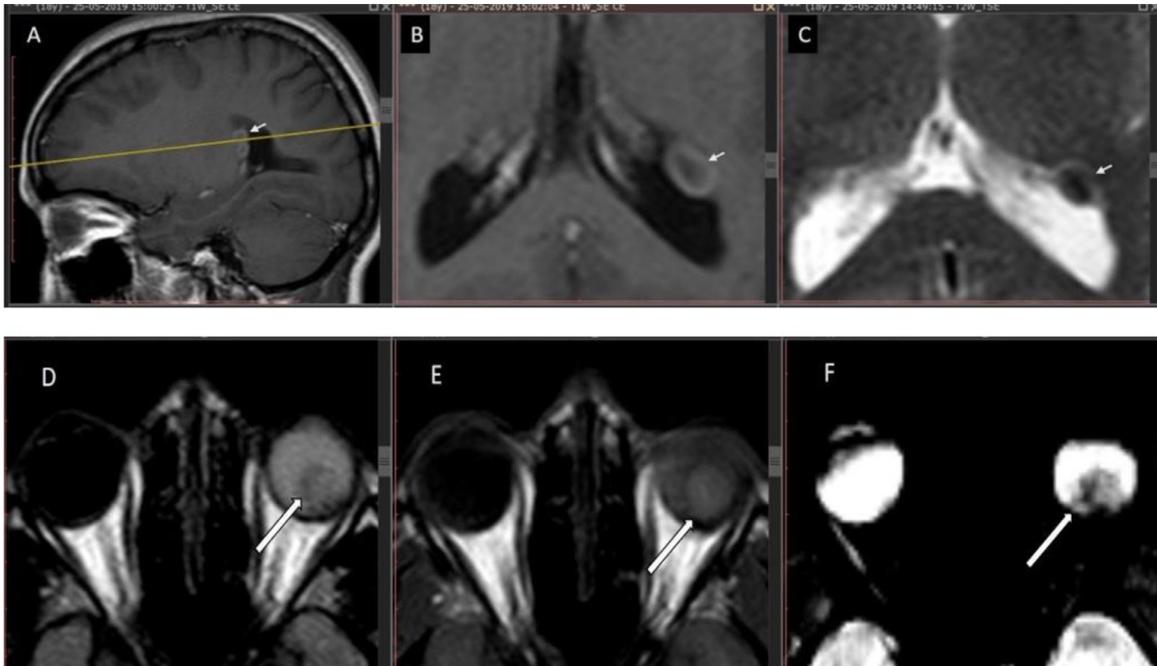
Contrast-enhanced MRI Brain shows round to oval enhancing mass lesion (white arrows) arising from the antrum of the left lateral ventricle (A and B), in close proximity to the foramen of Monroe appearing peripherally hyperintense with central hypointensity on T2W image (C) and shows round to oval enhancing mass lesion (white arrows) arising from juxta-papillary location of left globe, iso to hypointense on FLAIR (D), mildly hyperintense compared to surrounding media on T1W image (E) and blooming foci on T2 (F).
